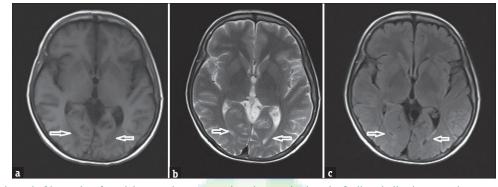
(a-c) At the end of 3 months of cranial magnetic resonance imaging monitoring, the findings indicating posterior reversible encephalopathy syndrome had decreased
